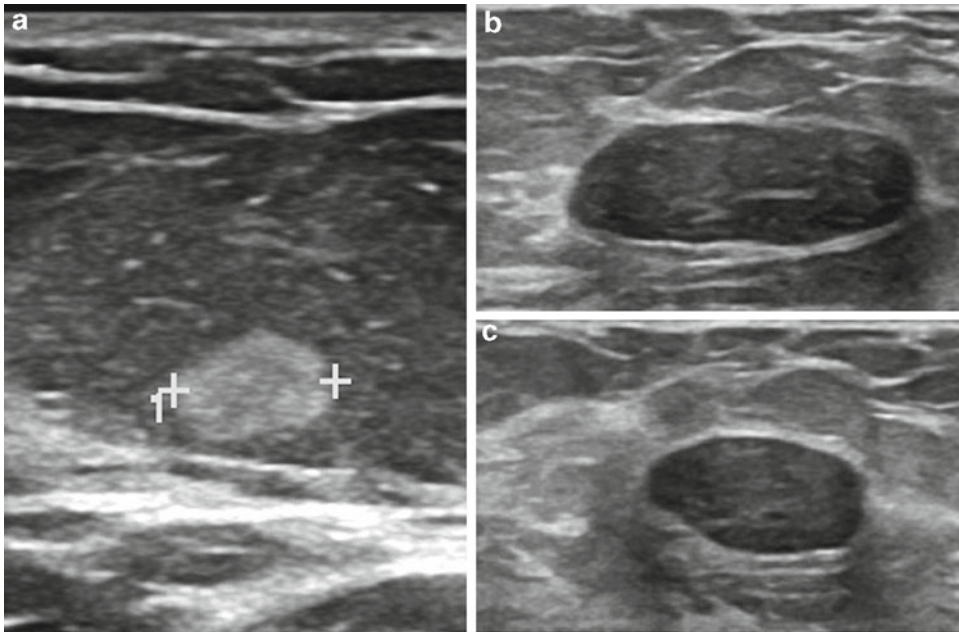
Palpable solid masses demonstrating benign sonographic features. (a) Circumscribed uniformly hyperechoic mass. (b) Ellipsoid shaped solid mass with benign features. (c) Ellipsoid shaped solid mass with benign features
